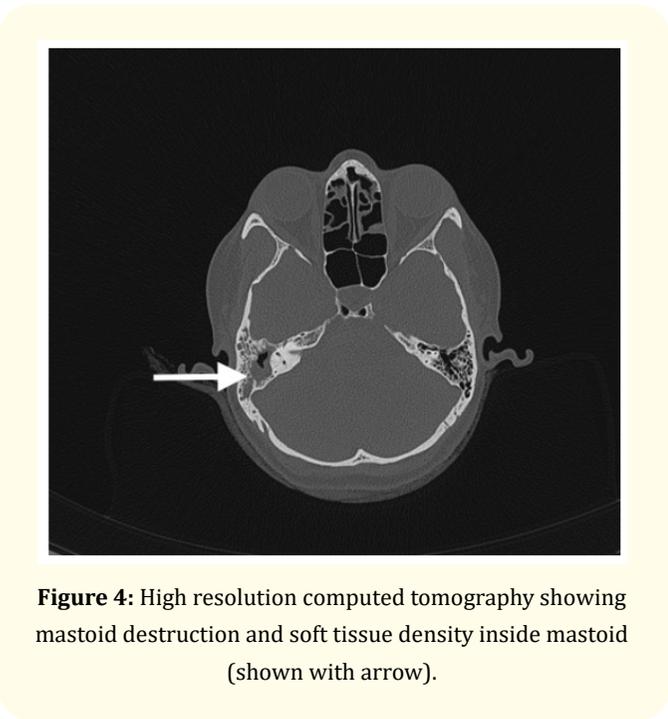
High resolution computed tomography showing mastoid destruction and soft tissue density inside mastoid (shown with arrow).
